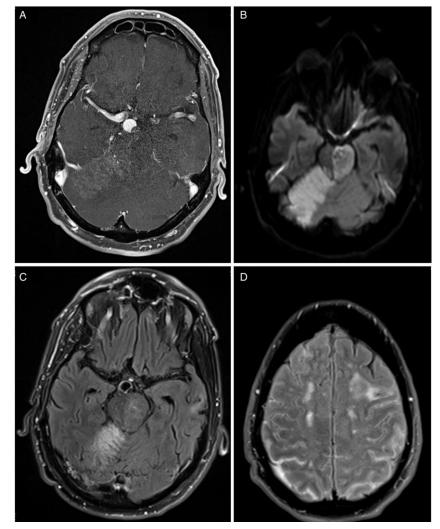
MRI (A) Longitudinal relaxation time (T1)-Volumetric interpolated breath-hold examination (VIBE) post contrast demonstrated interval progression of thrombus to distal basilar artery segment compared to CTA performed 2 days earlier, despite thrombolysis; (B) DWI: acute pontocerebellar infarcts; (C) Fluid-attenuated inversion recovery (FLAIR) post contrast: basilar artery wall circumferential mural enhancement (inflammation versus slow flow), and (D) acute subarachnoid hemorrhage.
